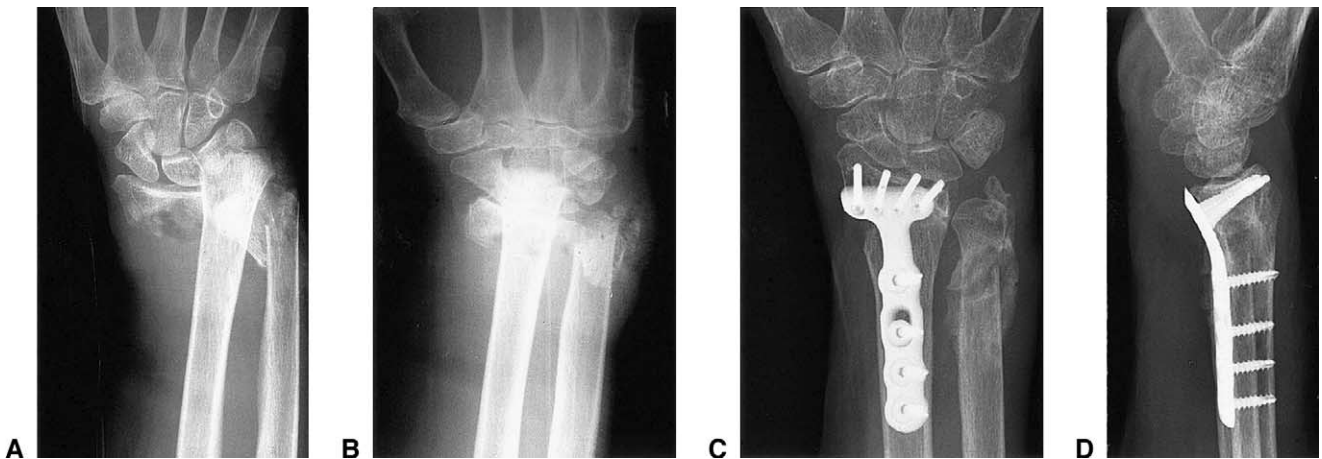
(A) Anteroposterior and (B) lateral preoperative films of an 85-year-old patient with an unstable extra-articular distal radius fracture plus distal ulnar fracture. Postoperative x-rays, (C) anteroposterior and (D) lateral, at 4 months after fixation showing proper correction of the radial length, volar tilt, and complete healing of the distal radius and distal ulna (patient 22, Table 1).
